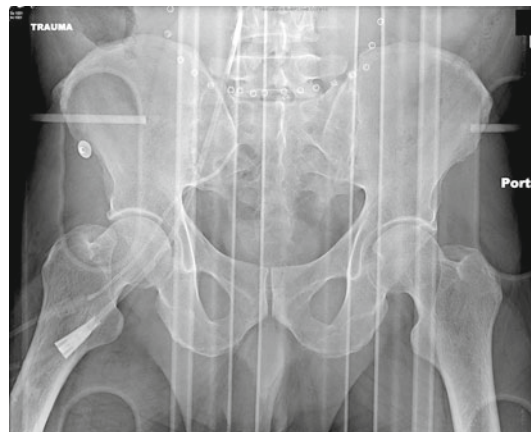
AP X-ray of the pelvis, demonstrating fused SI joints
